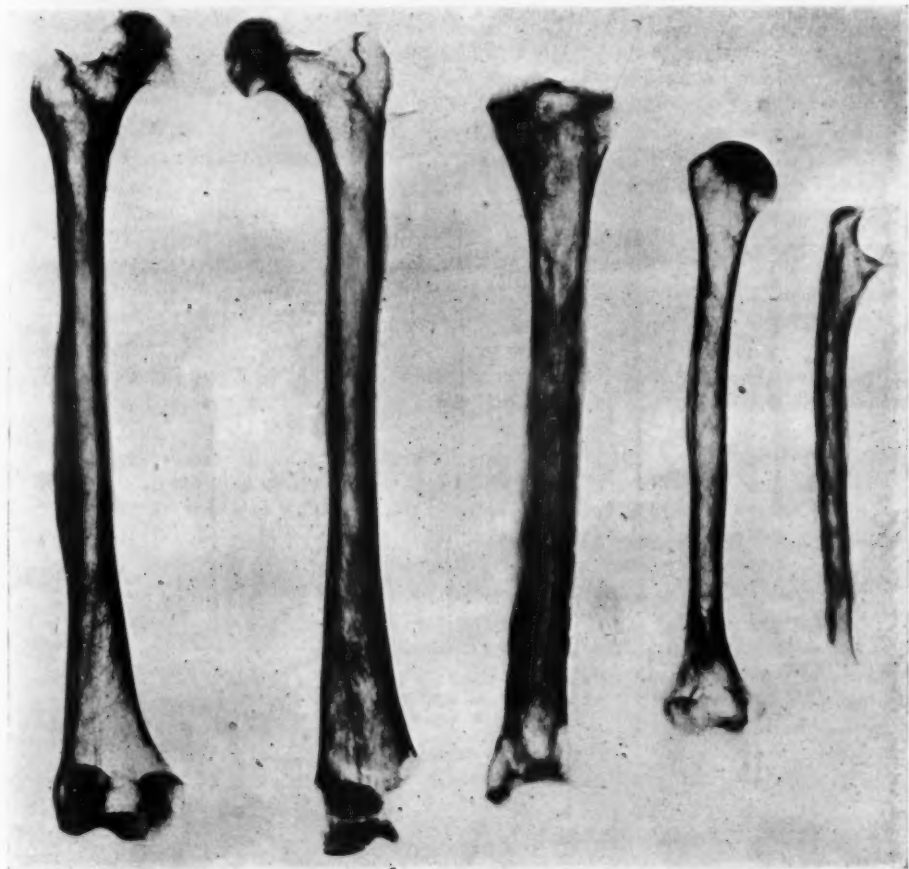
Long bones, case 12-7509. The roentgenogram reproduced here was one of the best examples of the roentgenologist's art that I have seen; it has suffered greatly in being reduced in size and in the loss of detail in the process of photo-engraving. It was made by Dr. Oscar Soto, Loayza Hospital, Lima, Peru.
